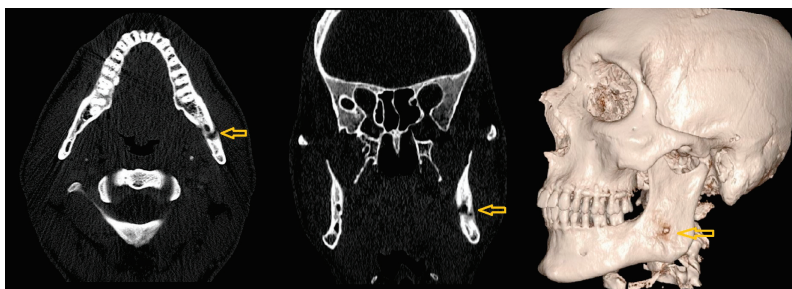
Axial (left), coronal (middle), and 3D reconstructed (right) CT images showing a localized area of osteolysis in the left mandibular body at the level of the mandibular canal (yellow arrows).
